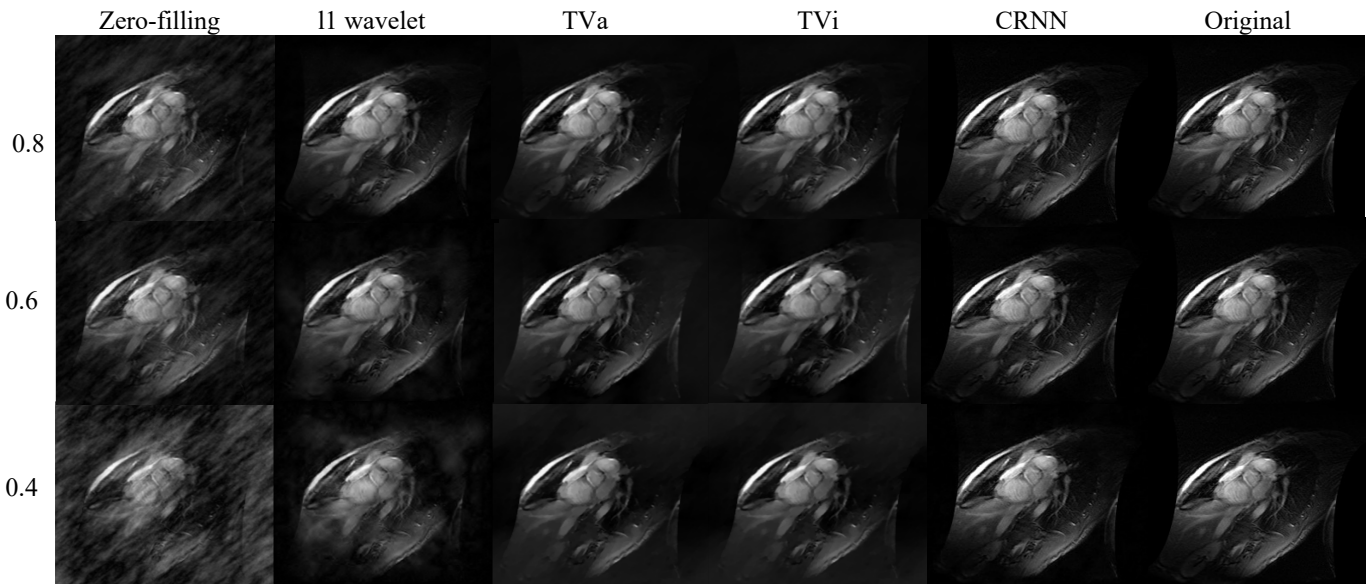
Reconstructed cardiac MR images based on different methods.
